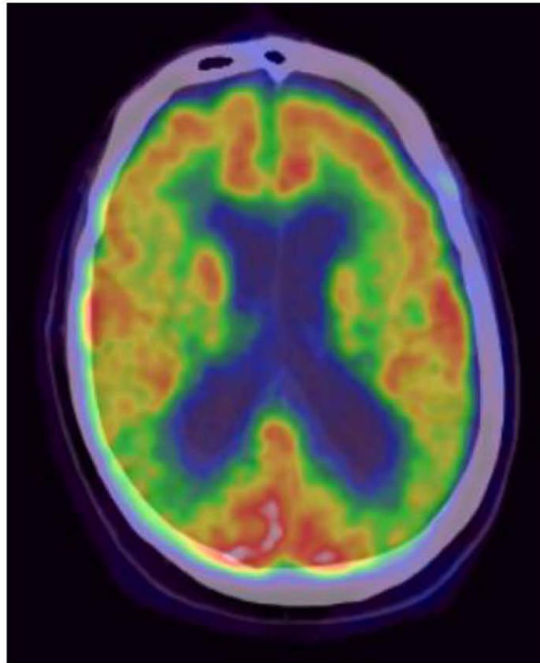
An example of an PET-FDG scan
